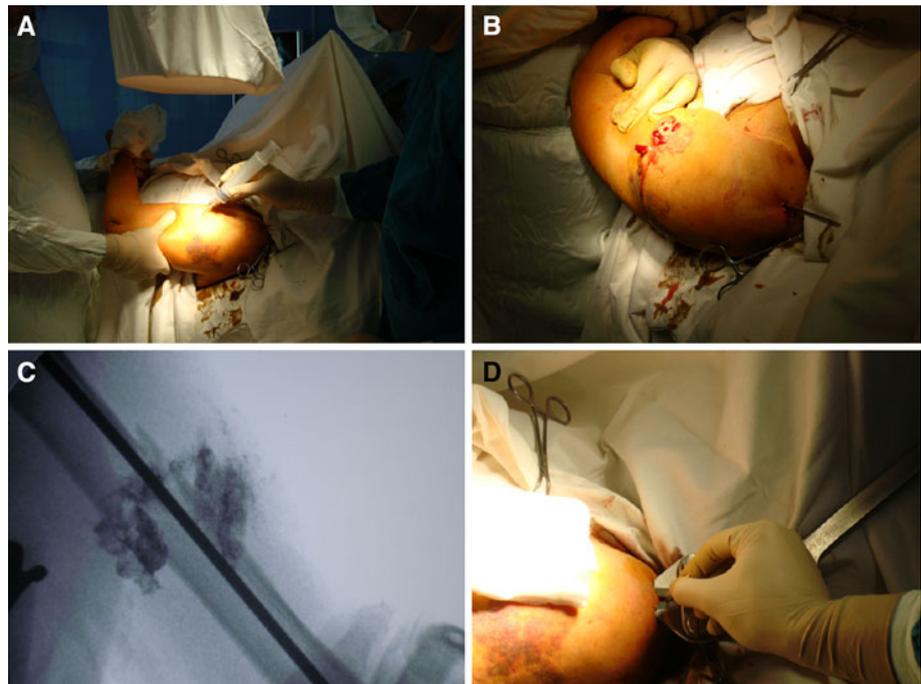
a Humerus shaft fracture—reduction, 18 G needle placement, cement injection, b Fracture dislocation—orthopaedic reduction, and percutaneous X-ray osteosynthesis at 3 weeks (c)
